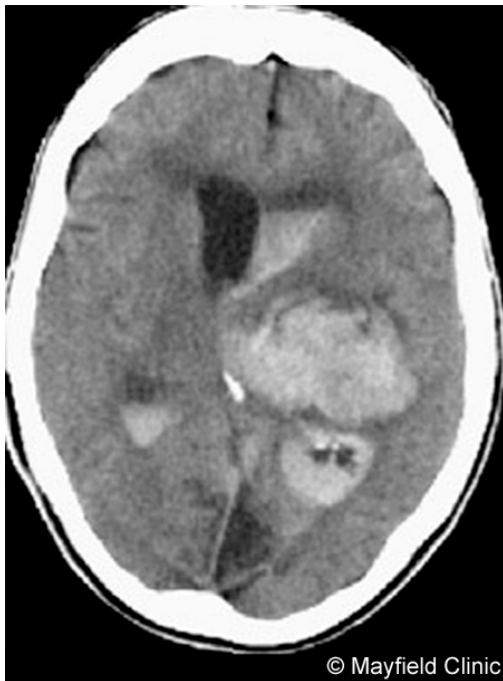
CT scan showing a large ICH.
